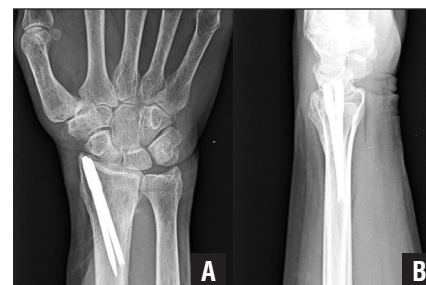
Final posteroanterior (A) and lateral (B) radiographs of a patient whose final Disabilities of the Arm, Shoulder and Hand score was 35. The patient required carpal tunnel release 6 months after fracture fixation.
